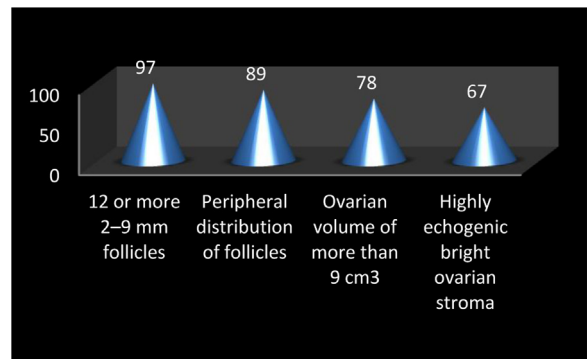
The distribution of ultrasound criteria of PCOS in the study (N = 108).
